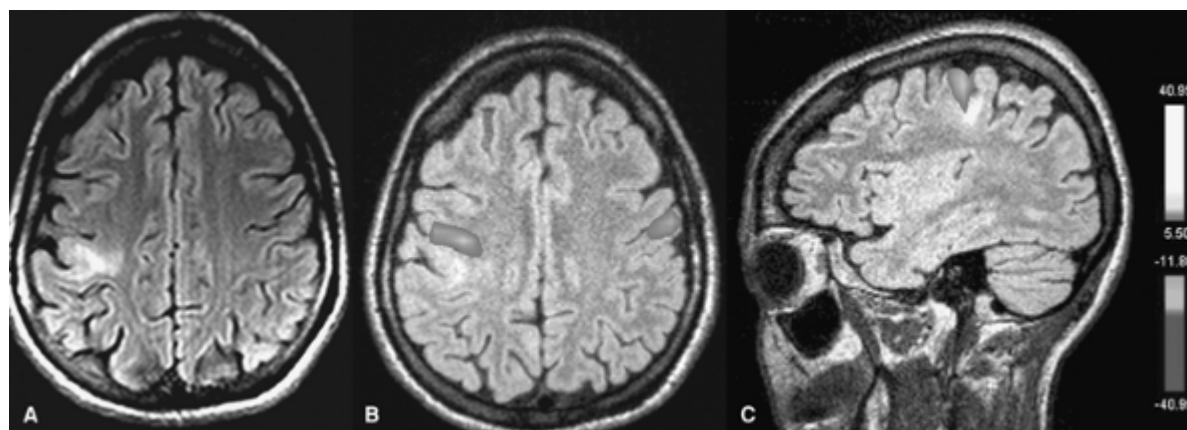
A 25-year-old female with daily refractory focal seizures characterized by paresthesia and tonic posturing of left upper extremity, occasionally progressing on to the left lower extremity since the age of 10 years. A: Axial fluid attenuated inversion recovery magnetic resonance imaging (MRI) sequence shows a focal cortical malformation in the right sensorimotor cortex. Inline blood oxygenation level-dependent functional MRI axial (B) and sagittal (C) during left finger tapping versus rest show right motor activation very close and within the lesion. Surgery was deferred in view of the high likelihood of postoperative left upper extremity weakness.
